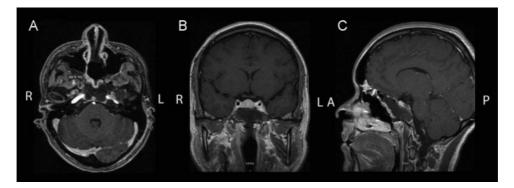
Magnetic resonance imaging axial (A), coronal (B), and sagittal (C) showing significant reduction in size of lesion. There is decreased mass effect over the internal carotid arteries. The pituitary stalk is midline and there is no compression of the optic chiasm.
